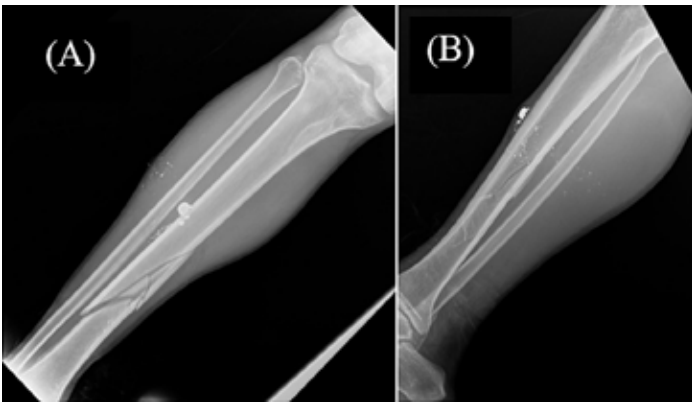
(A) AP and (B) lateral x-ray of the right tibia and fibula demonstrating a comminuted midshaft tibia fracture.
